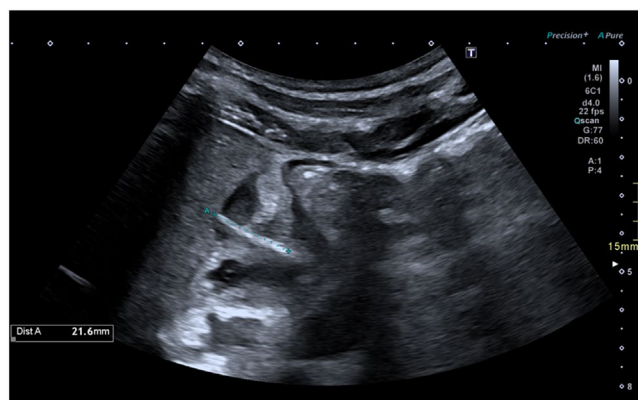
Ultrasonography image showing fish bone (blue caliper) measuring 21.6 mm.
